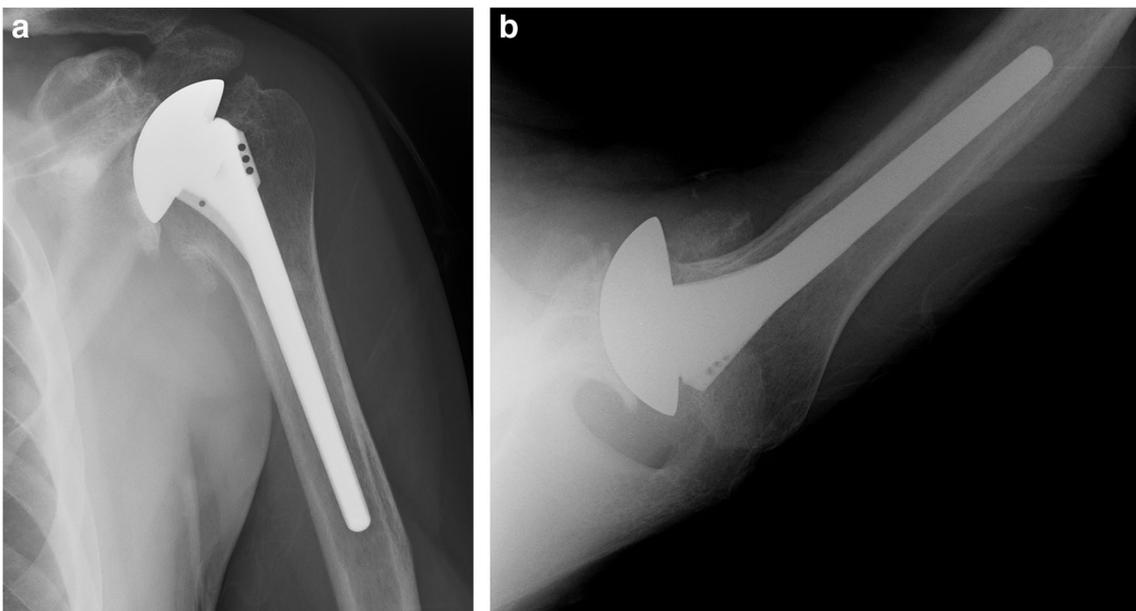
Case 2. a Post-operative AP and b axillary radiographs showing centering of an anteriorly eccentric humeral head in the reamed glenoid, and the fixation of a smooth stemmed humeral component with impaction autografting
